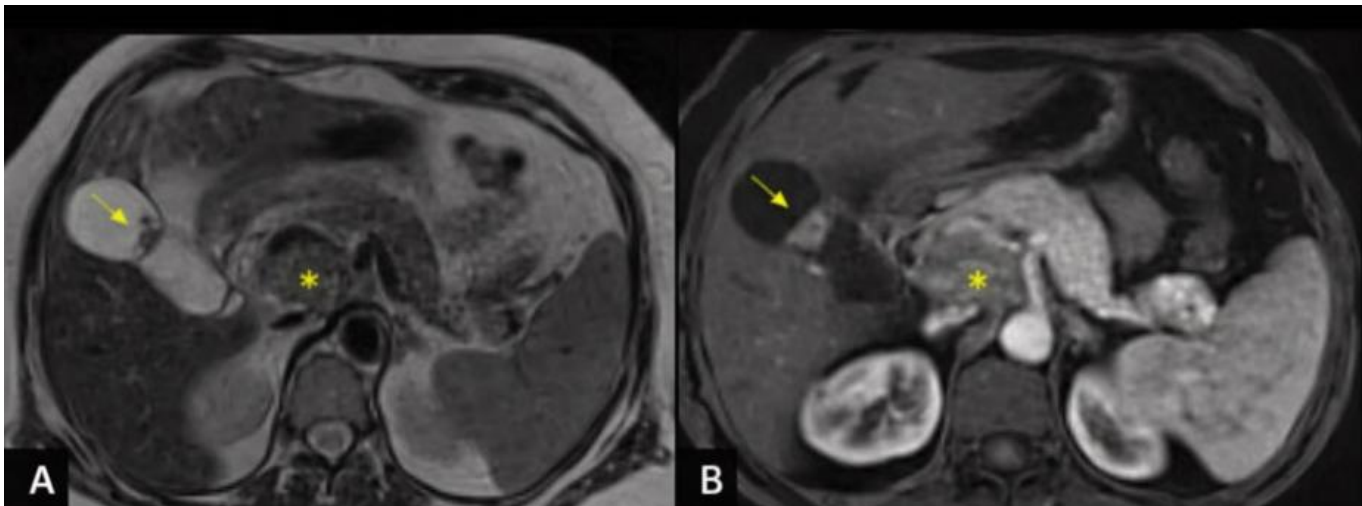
MRI of intracystic papillary neoplasm of the gallbladder (arrow) associated with pancreatic ductal adenocarcinoma (*) on T2 (A) and T1 with injection (B) sequences
